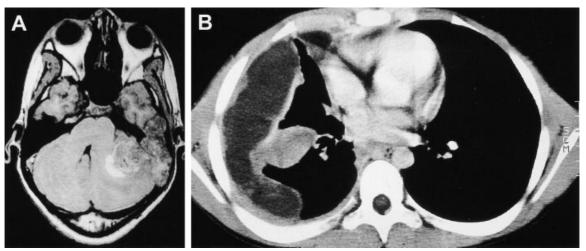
(A) MRI of head. A large tumor destroying the petrous bone and invading the cerebellum. (B) MRI of thorax. A large right-sided mass is seen, thickening the pleura and compressing lung tissue.
